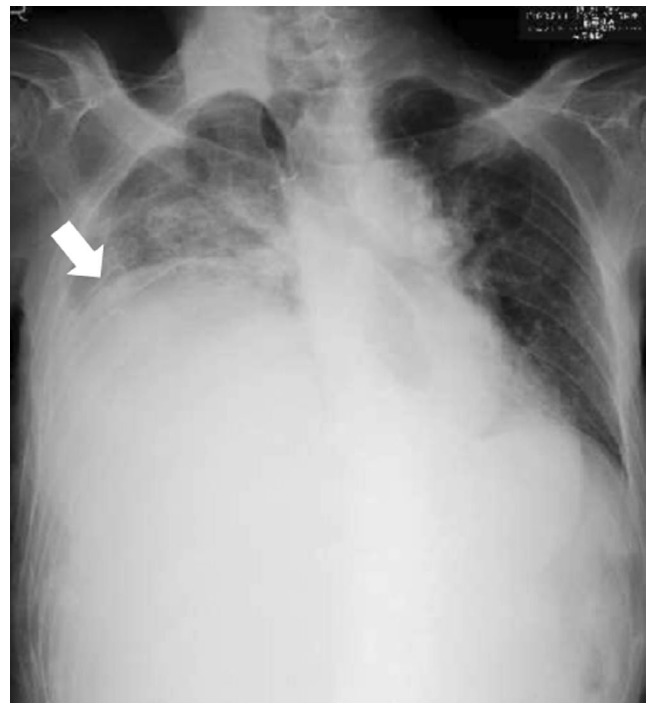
Anterior-posterior chest radiograph demonstrating elevated right hemidiaphragm compressing the right lung (arrow)
